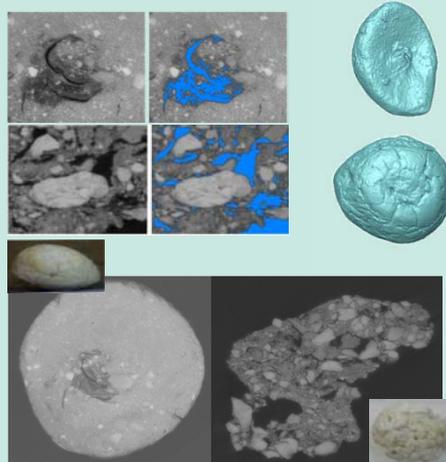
Reconstructed 3D XCT image of a calcinosis sample (top right) and photographs (insets) of two samples of calcinosis and corresponding computed tomography images (bottom). XCT images showing the pores present in the calcinosis and highlighted in blue are also shown (top left)
